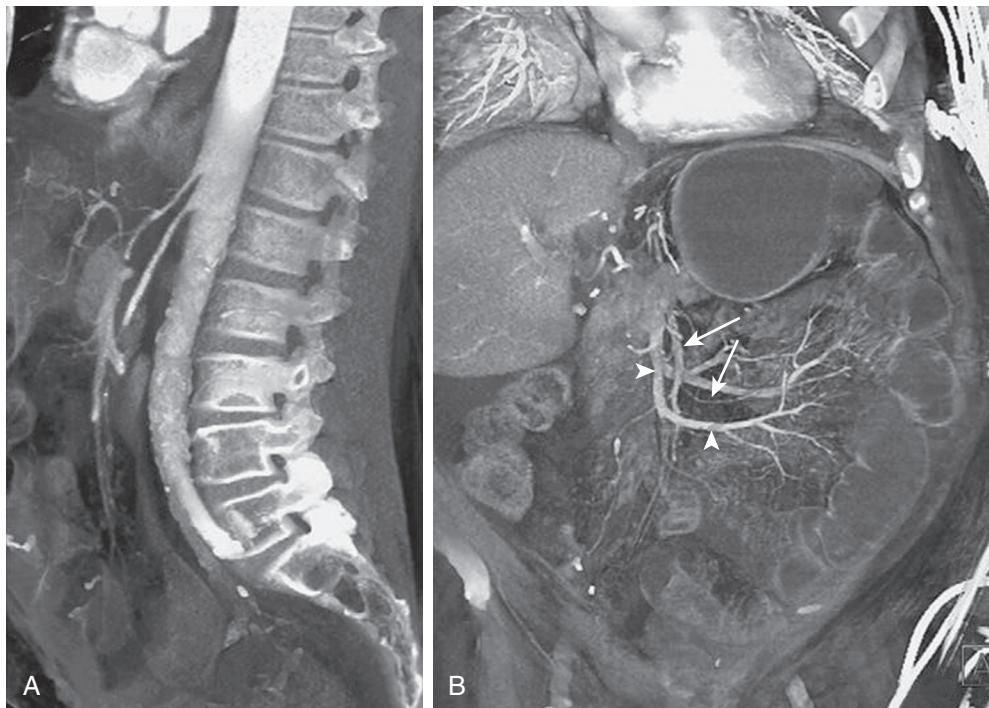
Computed Tomographic Angiography Appearance of Nonocclusive Mesenteric Ischemia. (A) Sagittal volume-rendered image shows diffuse narrowing of the main celiac and superior mesenteric arteries. (B) Coronal oblique volume-rendered image of the same patient shows pruning of the superior mesenteric artery branches (arrows). Note the dilated fluid-filled small intestine and the superior mesenteric vein (arrowheads). (From Horton KM, Fishman EK. Multidetector CT angiography in the diagnosis of mesenteric ischemia. *Radiol Clin North Am*. 2007;45:275–288.)
